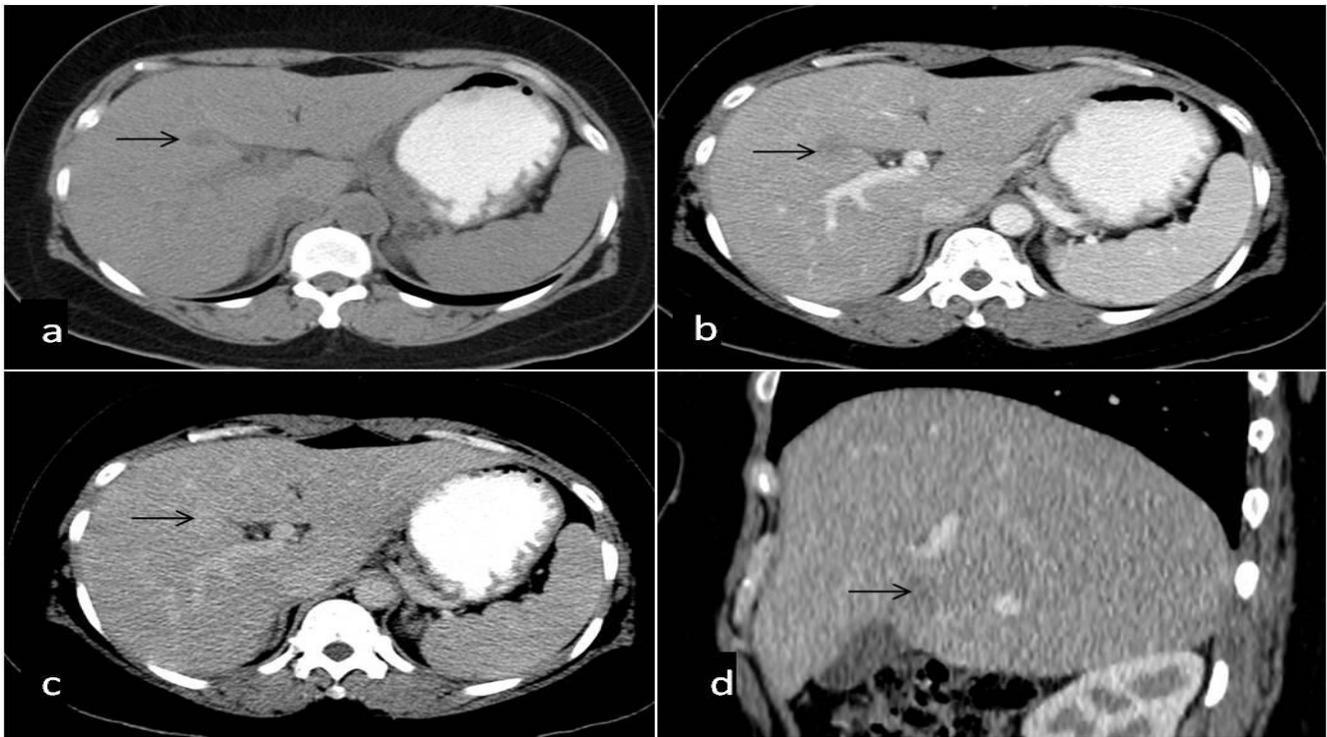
Axial CT scan non contrast (a) images and post contrast images in portovenous (b) and delayed phase (c) images show a hypodense nodule (arrows) which is hypoattenuating to liver parenchyma on non contrast and post contrast portovenous phases, while is hyperattenuating on delayed phase images. (d) Sagittal reformatted image shows peripheral location of the lesion.
